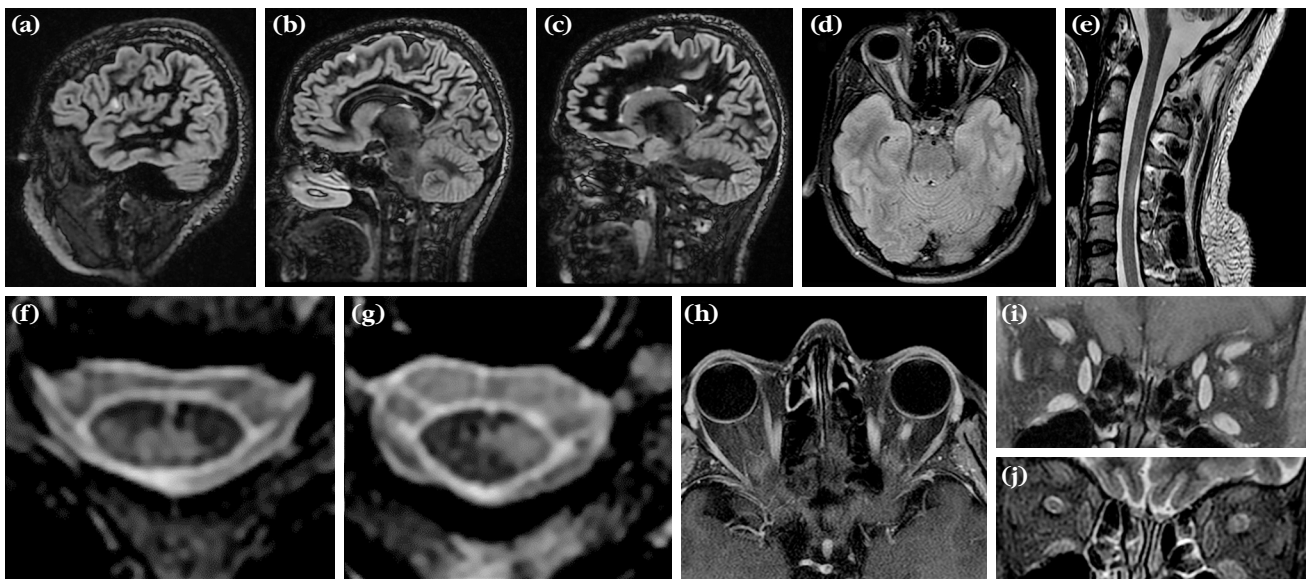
Magnetic resonance imaging sequences demonstrate the five central nervous system topographic regions for dissemination in space. At least one lesion must be present in two or more of the five CNS regions. (a) Cortical lesion on sagittal DIR, (b) juxtacortical and periventricular lesions, (c) infratentorial and periventricular lesions, (d) right optic nerve lesion infratentorial lesion on axial FLAIR, (e) sagittal T2-weighted image showing a spinal cord lesion, (f, g) Axial STIR images of cervical spinal cord lesions in different segments. (h, i, j) left optic nerve involvement, (h, i) contrast enhancement of the anterior left optic nerve on fat-saturated T1-weighted image; (j) enhancement and thickening of the left optic nerve on coronal STIR image.
